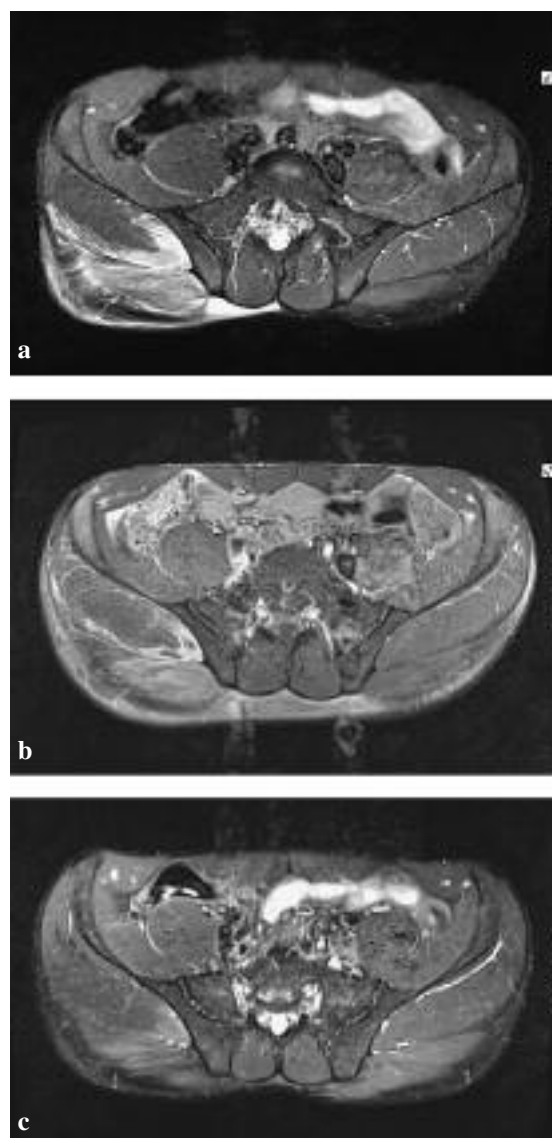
a) Inversion recovery axial MR images performed 24 hours after injection show extensive oedema in the subcutaneous fat extending to the midline posteriorly. There is also extensive oedema throughout the superior aspect of the gluteus maximus and the medial aspect of the gluteus medius associated with inter-muscular fluid. The needle track can be seen as a straight high signal line extending to the deep aspect of the gluteus maximus. The T1 weighted images showed no evidence of acute haemorrhage.
